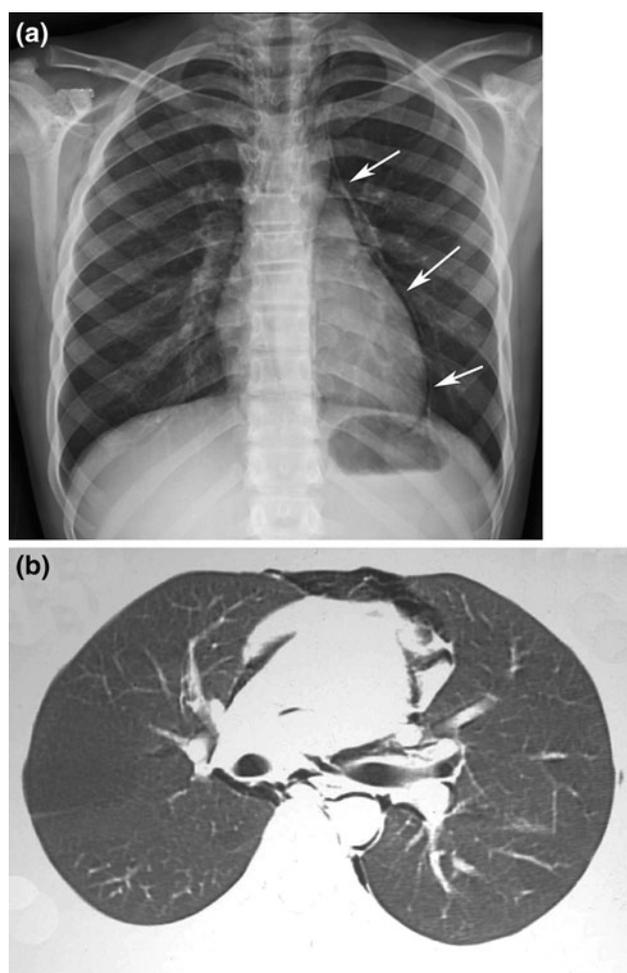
Pneumomediastinum in a 23-year-old man who had smoked crack cocaine. The patient presented with chest pain and had no history of trauma. a Chest X-ray shows a lucent line (arrows) extending into the *left* mediastinum. b HRCT reveals free air dissecting the mediastinal structures, bronchi, and pulmonary vessels
